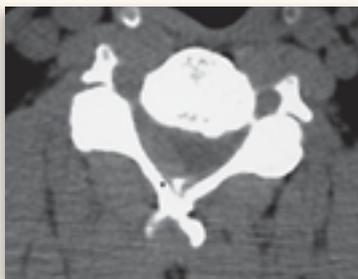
Computed tomography scan at the level of C4 vertebra showing an epidural hematoma pushing the spinal cord to the left and forward
